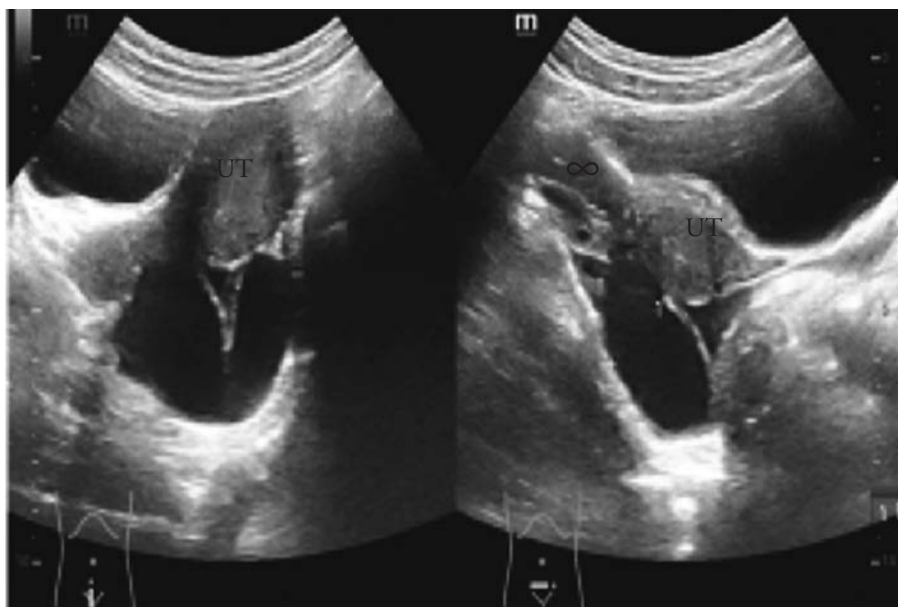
Ultrasound showing torsed fallopian tube, forming a "C" shape
